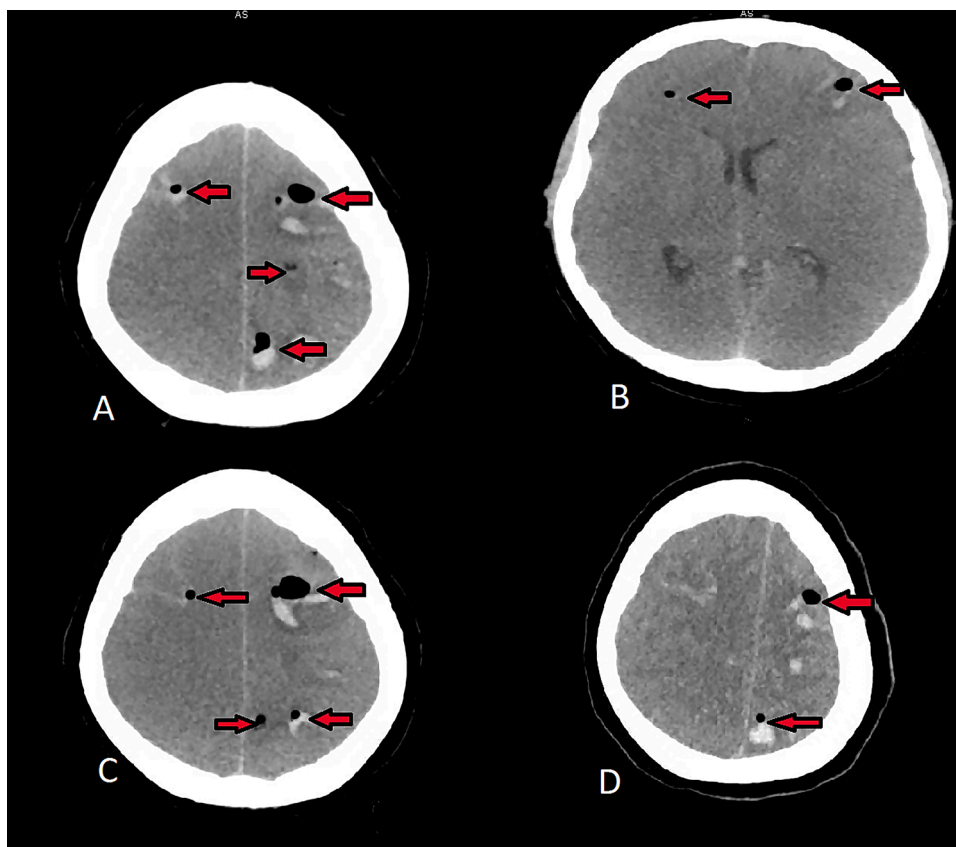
CT head: Remarkable for multiple air pockets in the brain parenchyma with no air fluid levels.
